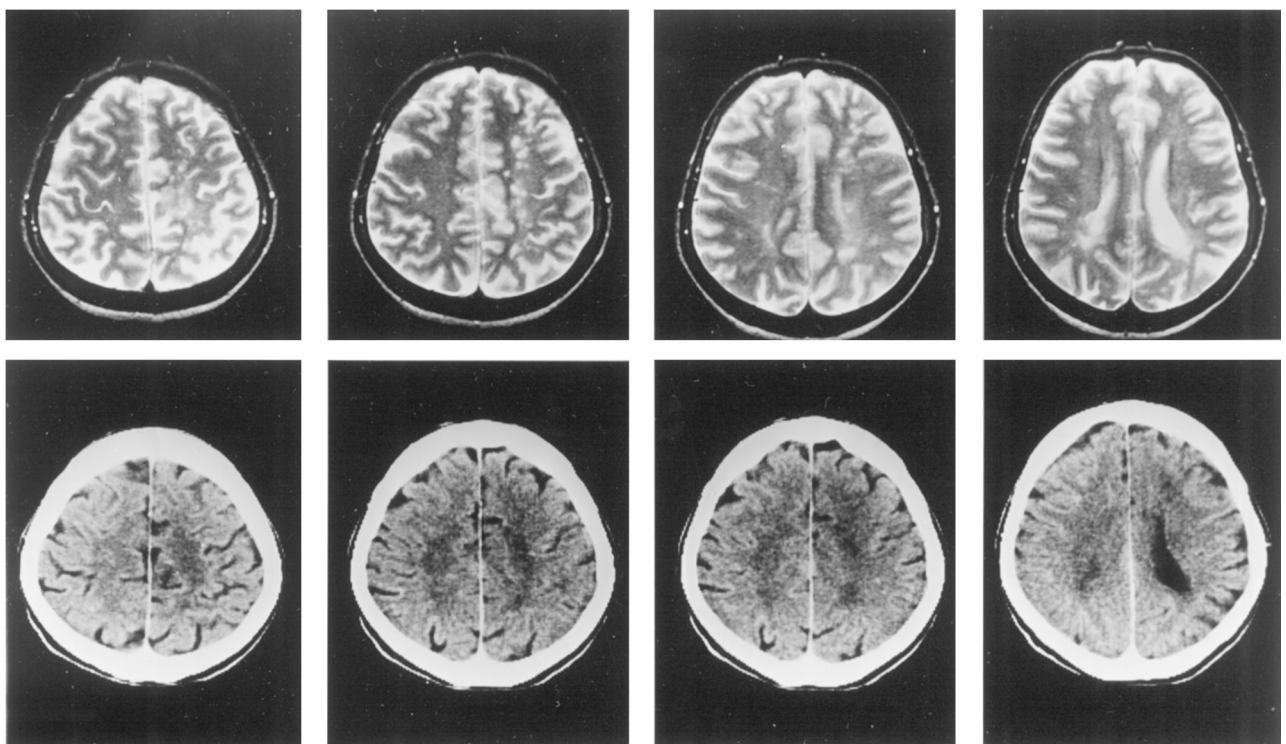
MR images (top row) and CT scans (bottom row) in patient 1.
